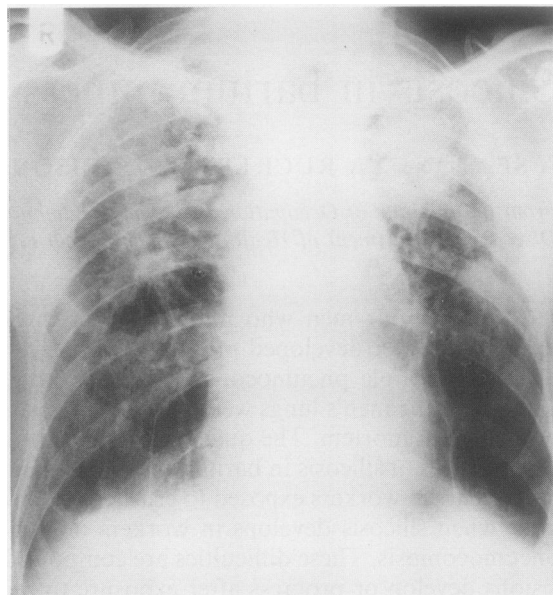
Posteroanterior radiograph of patient 2 showing bilateral upper zone progressive massive fibrosis with lower zone emphysema.
